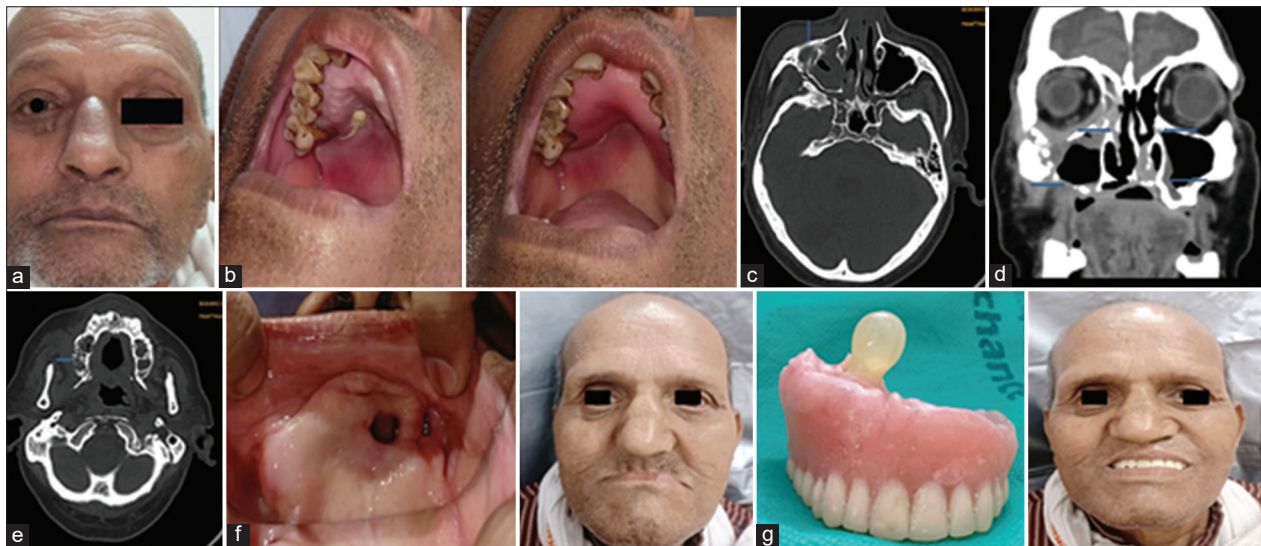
(a) Swelling of right upper half of face, redness around eyes and right side proptosis, (b) Intraoral palatal fistula covered with necrotic slough with Palatal obturator to prevent nasal regurgitation, (c) Computed tomography (CT) scan coronal section showing inhomogeneous soft tissue densities, (d) CT scan coronal section showing mild proptosis, (e) CT scan axial section showing bony erosion and destruction of the right superior alveolar ridge, (f) Post-operative clinical image intraoral and extraoral of patient, (g) Post-operative rehabilitation done with removable partial denture with obturator (Case 2)
